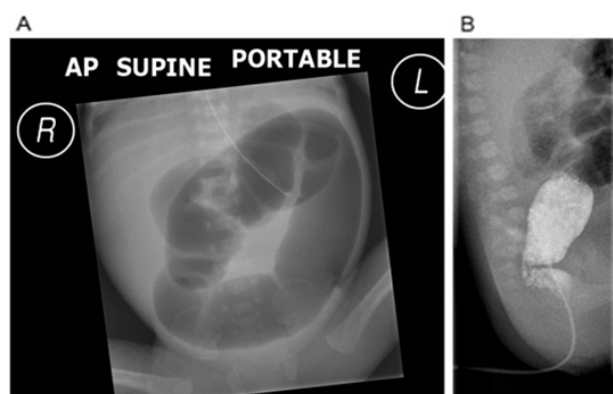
Plain abdominal radiograph and contrast enema of Case 1
